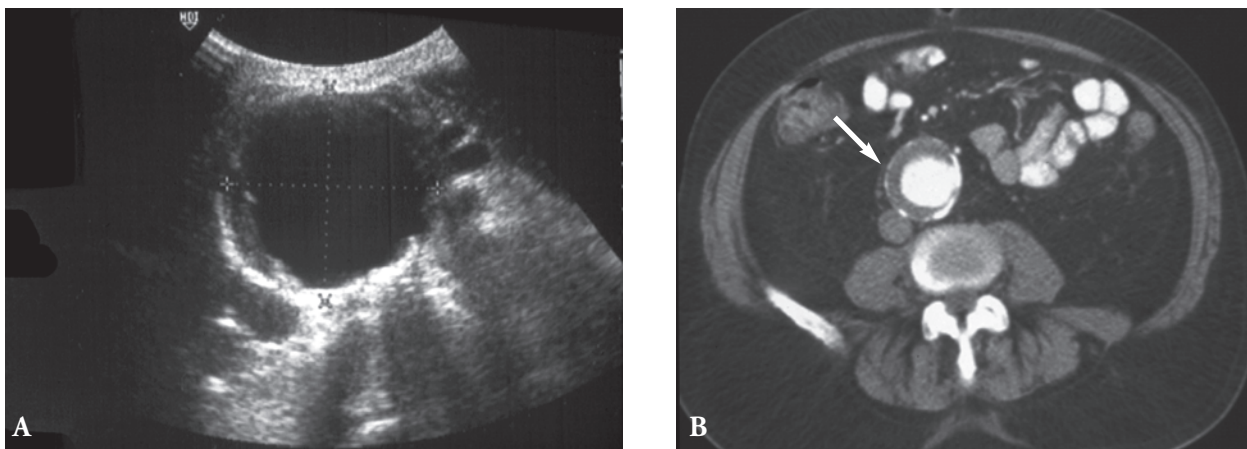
A*, Ultrasonogram (transverse view) shows a 4.7-cm abdominal aortic aneurysm. *B*, Computed tomogram (contrast-enhanced) shows an abdominal aortic aneurysm with moderate mural thrombus.
